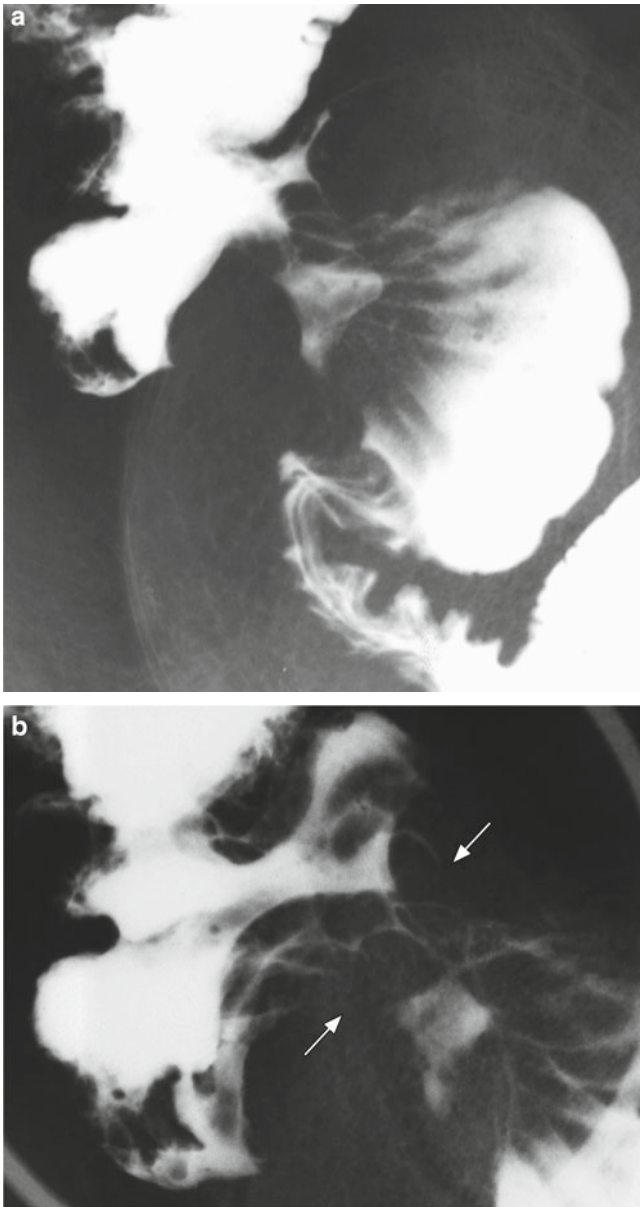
(a) Radiography (at the same period as Fig. 19.26 c, d) showed clearly demarcated pools of barium and convergence of intestinal folds in the ileocecal area. (b) Radiography (Fig. 19.26 c, d) revealed narrowing of the ileocecal area due to ulcer scarring
